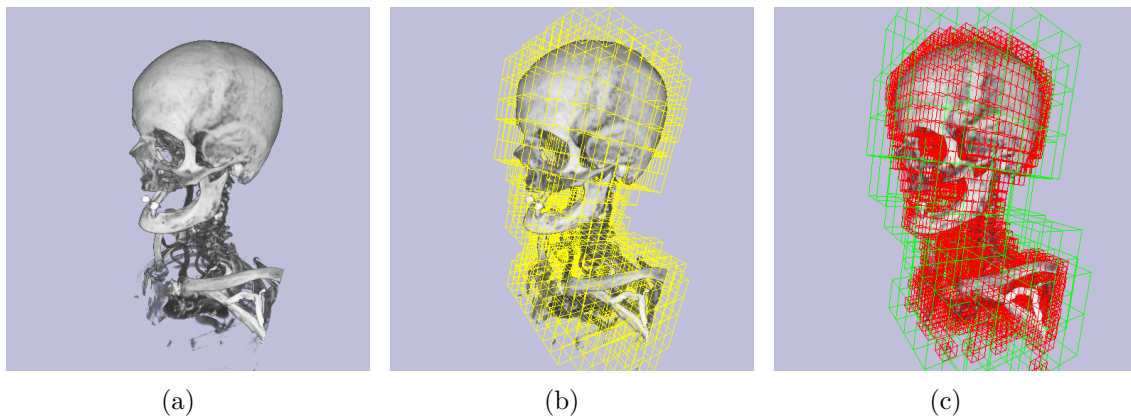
Examples for empty space skipping. (a) DVR of CT dataset and bone transfer function (b) Octtree based empty space skipping geometry. Active octtree cell boundaries rendered in yellow with DVR. (c) Two-level Brick/Block based empty space skipping. Active brick boundaries rendered in yellow, active blocks rendered in green.
